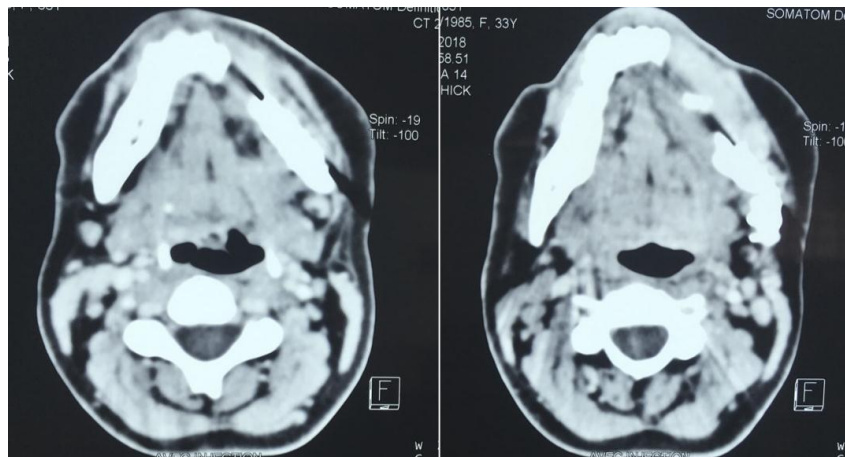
Axial CT images showing the recurrence on the tumor bed.
